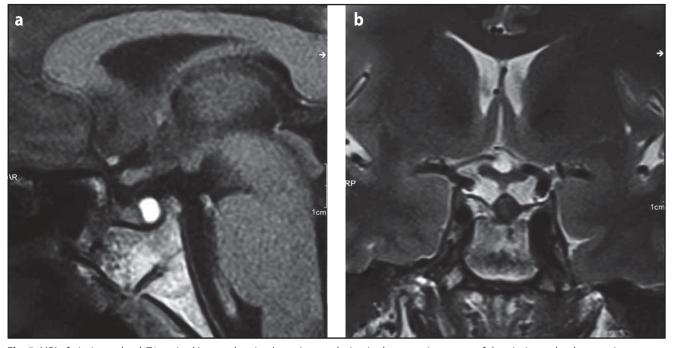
MRI of pituitary gland: T1 sagittal image showing hyperintense lesion in the posterior aspect of the pituitary gland measuring 5×7 mm (a); T2 coronal image showing hypointense lesion in the posterior aspect of the pituitary gland measuring 7×7 mm (b).
